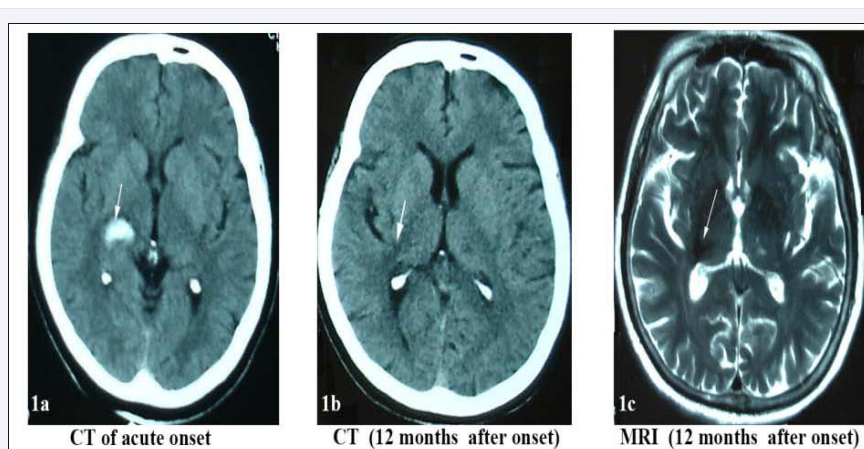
Skull image of case 1; 1a was CT scan on acute onset of thalamic hemorrhage; 1b was CT reexamination and 1c was T2WI /MRI of the patient at 1 year after the onset of ICH; The lesion was hypointense on T2WI.
